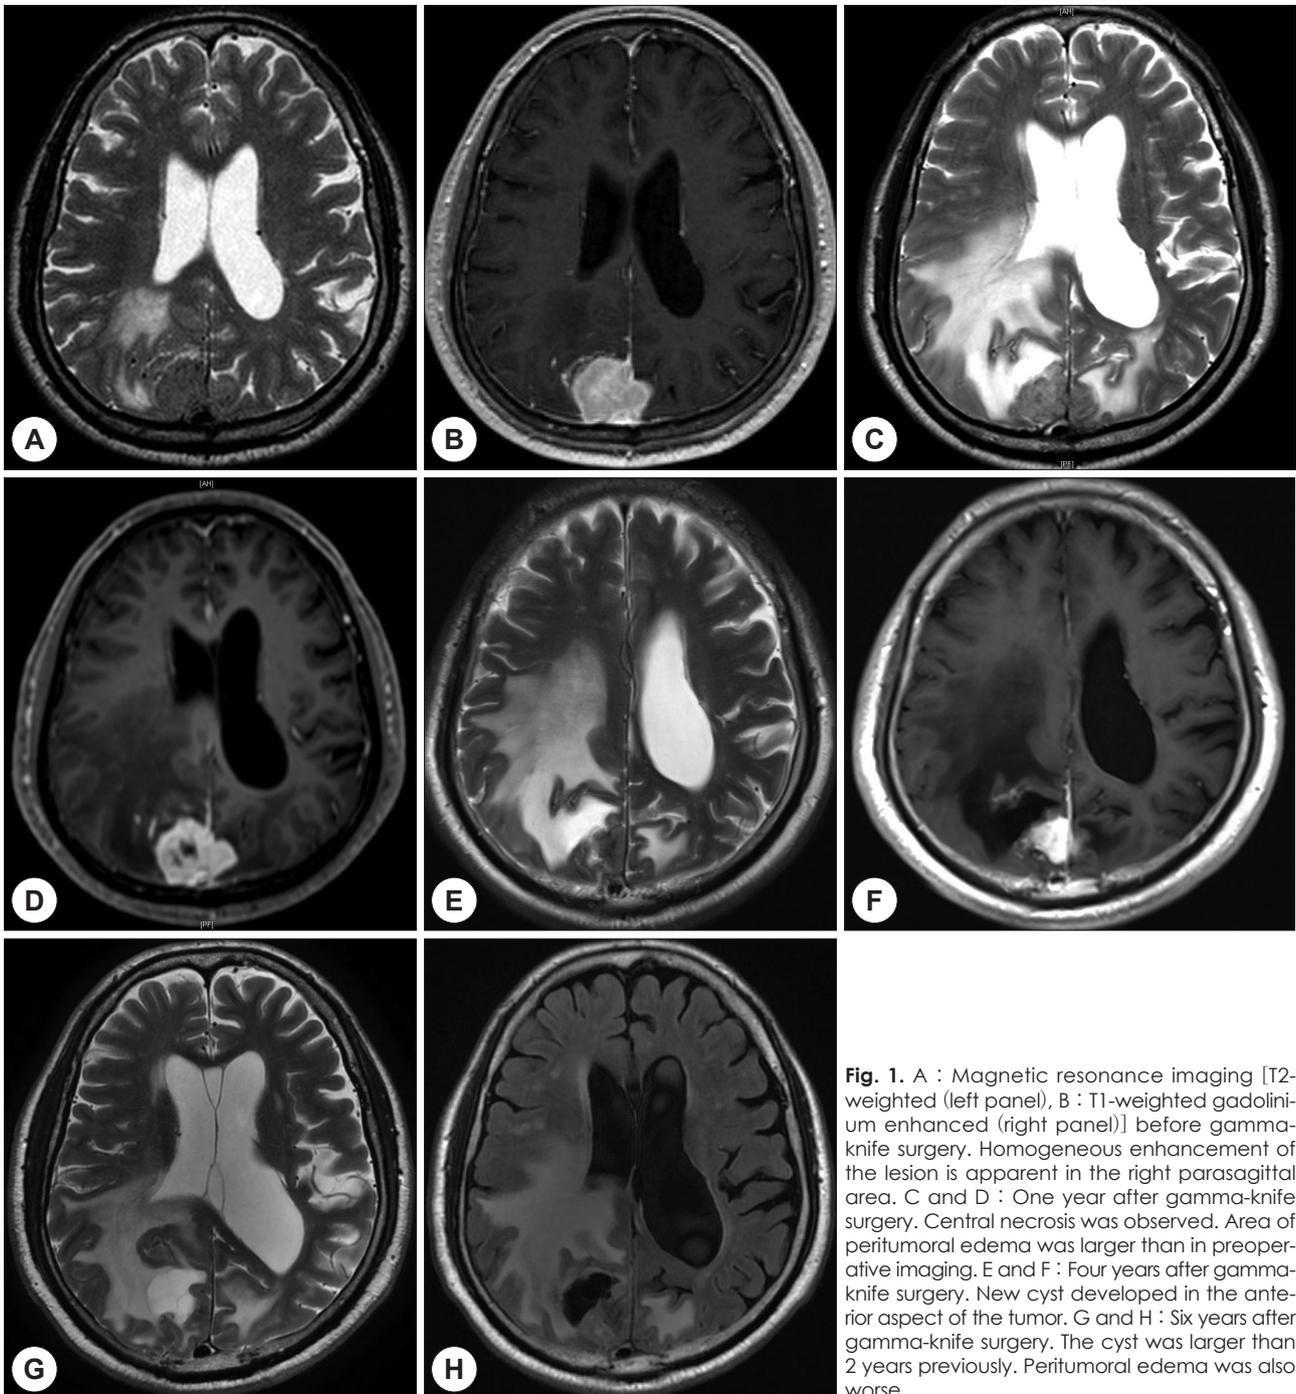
A : Magnetic resonance imaging [T2-weighted (left panel), B : T1-weighted gadolinium enhanced (right panel)] before gamma-knife surgery. Homogeneous enhancement of the lesion is apparent in the right parasagittal area. C and D : One year after gamma-knife surgery. Central necrosis was observed. Area of peritumoral edema was larger than in preoperative imaging. E and F : Four years after gamma-knife surgery. New cyst developed in the anterior aspect of the tumor. G and H : Six years after gamma-knife surgery. The cyst was larger than 2 years previously. Peritumoral edema was also worse.
